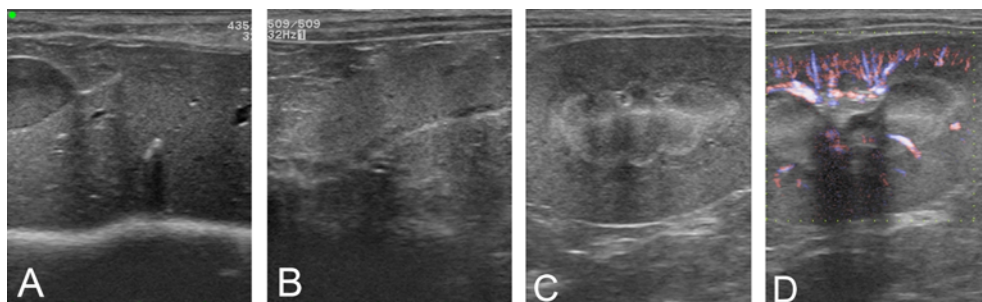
Ultrasonographic images of liver (A), spleen (B), and left kidney (C and D). The hepatic parenchyma is hyperechoic, with similar echogenicity to that of the splenic parenchyma. The left renal cortex is hyperechoic, but there is a normal vascular reaction on color Doppler ultrasonography.
